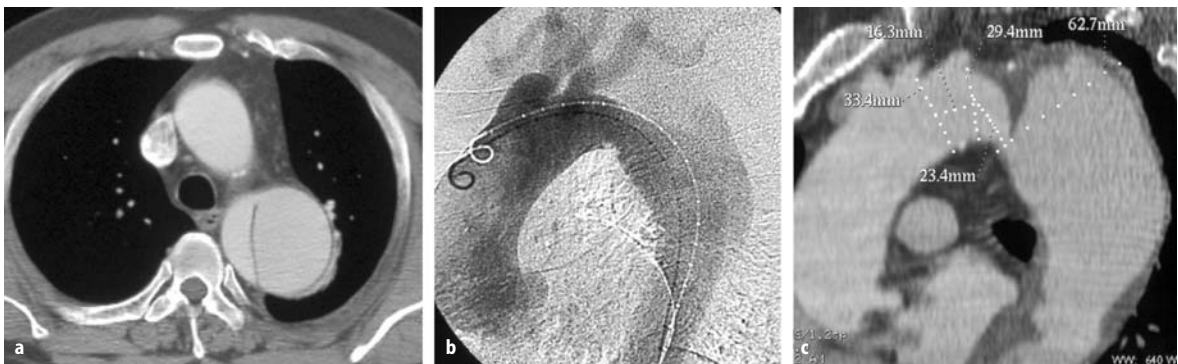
An axial computed tomography (CT) image shows the entry tear at the lesser curvature of the proximal descending thoracic aorta (a). However, the relation between the entry tear and the left subclavian artery cannot be recognized from this CT image. The location of the entry tear cannot be pointed out
